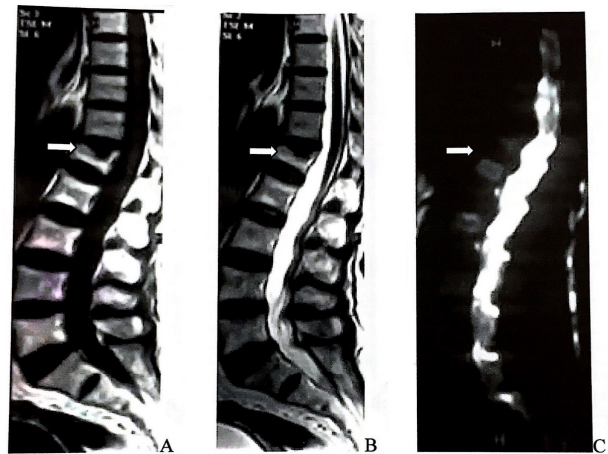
A 71-years-old female patient without malignancy (a) Sagittal T1W MRI, vertebral height loss was detected on first lumbar vertebra and isointense signal. (b) Sagittal T2W MRI showed loss of height in the L1 vertebra and isointense signal. (c) Diffusion MRI, L1 vertebra is isointense, there is no diffusion restriction; evaluated as a chronic stage benign vertebral fracture.
